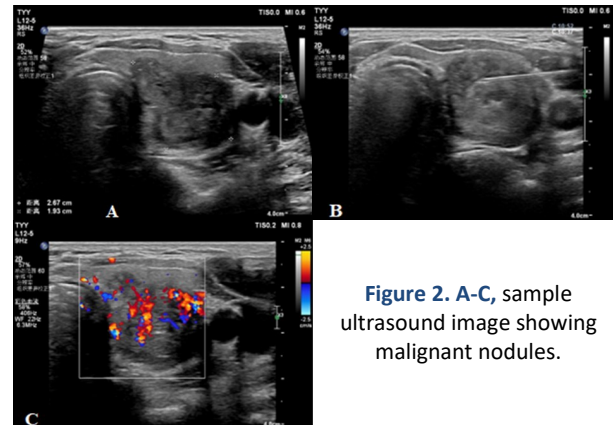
A-C, sample ultrasound image showing malignant nodules.
